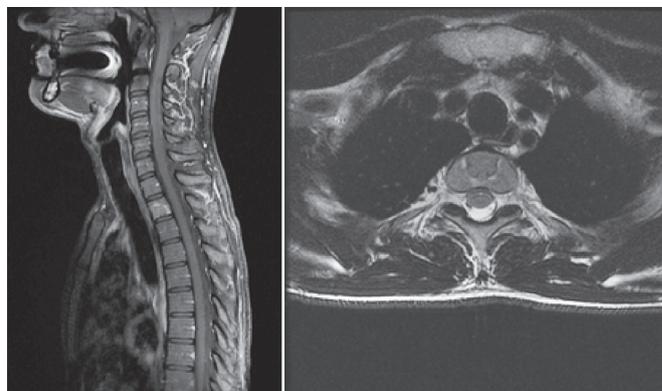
Magnetic resonance imaging (MRI) showing the lesion in T2.
